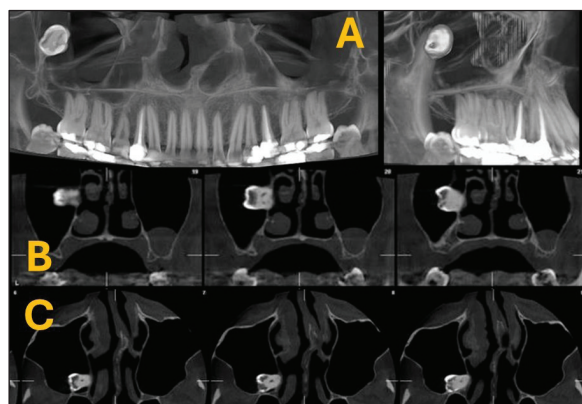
CBCT revealing the impacted ankylosed wisdom tooth in the lateral wall of the maxillary sinus (A). Coronal (B) and axial (C) views.
